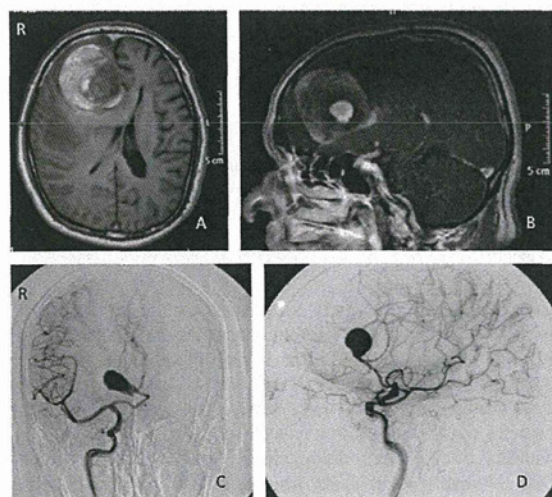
Axial (A) and Gd-enhanced sagittal (B) T1-weighted MR images of a patient (case 18) with a thrombosed aneurysm of the ACA. Anterior (C) and lateral (D) views of digital subtraction angiography showing an azygos ACA and a thrombosed aneurysm.
